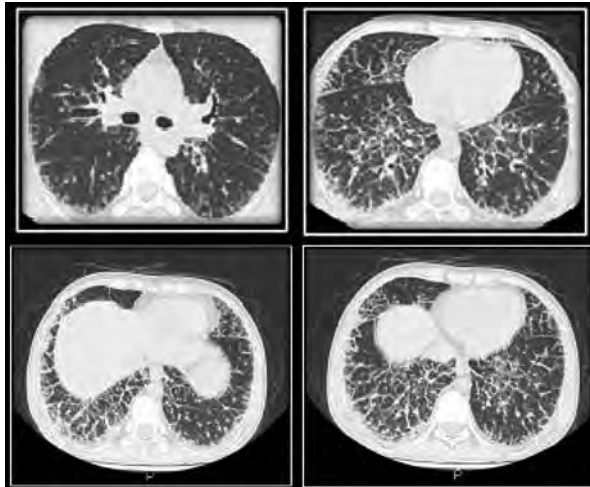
High-resolution computed tomography scan revealed diffuse crazy paving appearance in mid, and lower lobes of both lungs with ground glass opacity and coarse interlobular septal thickening
